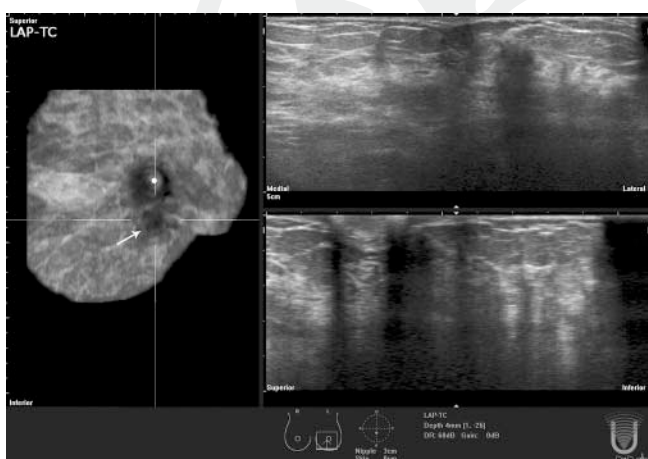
60-year-old woman with a hypoechoic area at 6.00, 3 cm from the nipple marker, directly under the skin (white arrow). 3/5 examiners classified this area as suspicious while 2 examiners recognized the area correctly as an artifact due to the lack of ultrasound gel.
